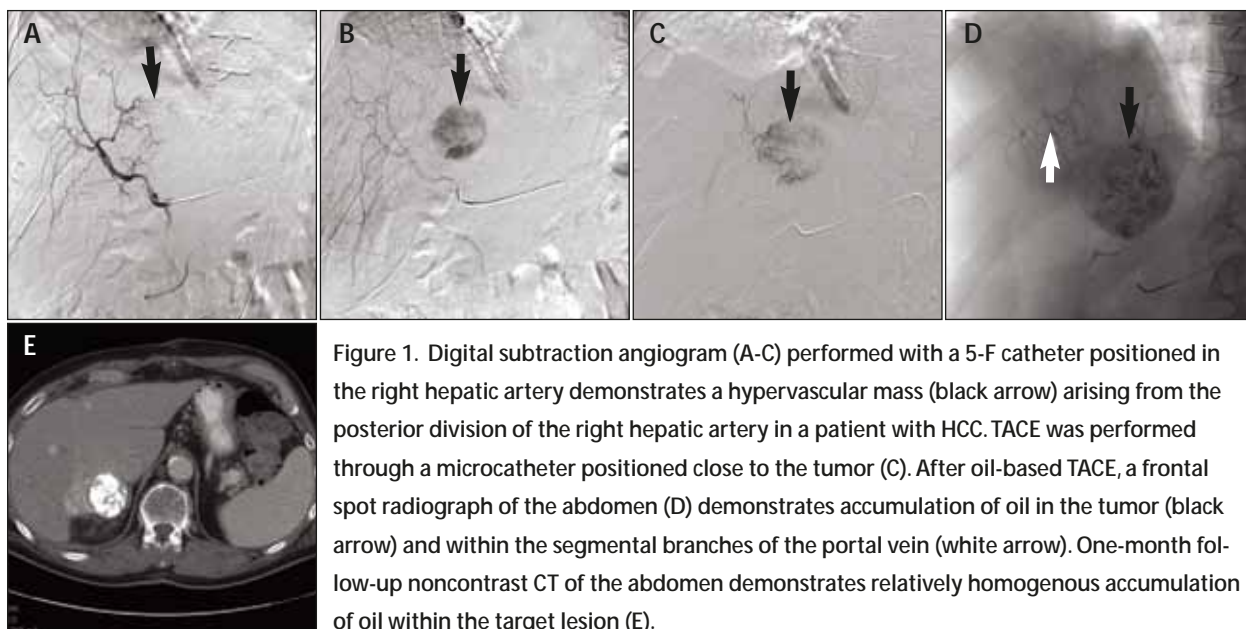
Digital subtraction angiogram (A-C) performed with a 5-F catheter positioned in the right hepatic artery demonstrates a hypervascular mass (black arrow) arising from the posterior division of the right hepatic artery in a patient with HCC. TACE was performed through a microcatheter positioned close to the tumor (C). After oil-based TACE, a frontal spot radiograph of the abdomen (D) demonstrates accumulation of oil in the tumor (black arrow) and within the segmental branches of the portal vein (white arrow). One-month follow-up noncontrast CT of the abdomen demonstrates relatively homogenous accumulation of oil within the target lesion (E).
